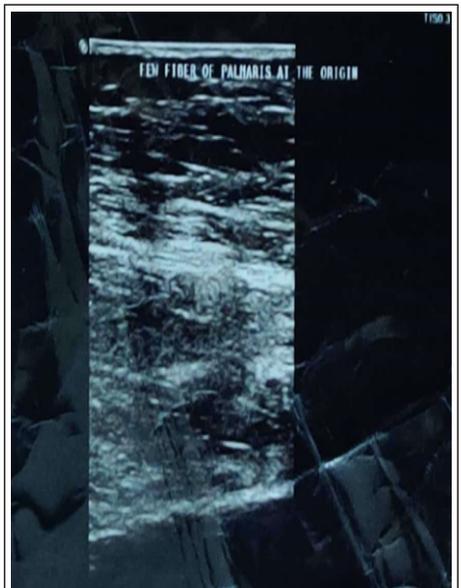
Ultrasonography showing prominent palmaris longus tendon.
